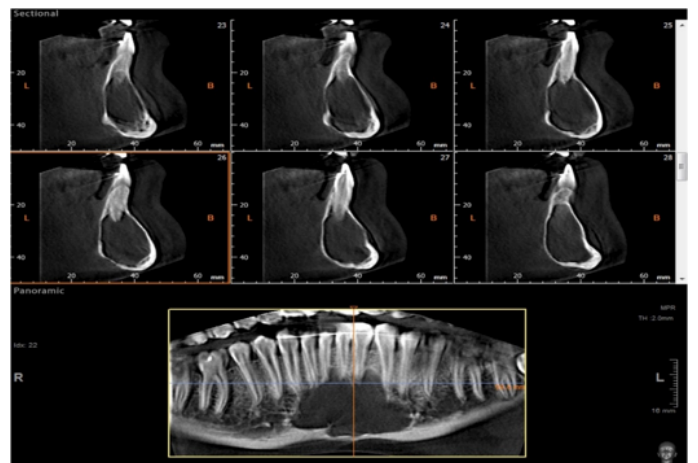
CBCT scan showed unilocular radiolucency at mandibular anterior region.
